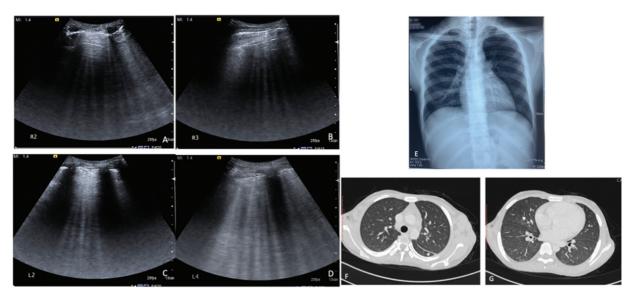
(A-G): Sagittal gray-scale ultrasound scans in a 15-year-old afebrile male presenting with dyspnea and cough revealed diffuse interstitial syndrome with multiple diffuse B-lines in >1 lung zones bilaterally in the form of 'Ground glass rockets'. (E) Chest X-ray in the same patient was however reported as normal. (F and G) CECT chest confirmed the findings of ultrasound with the presence of fissural thickening (arrow head) and ground glass opacities (arrow).
